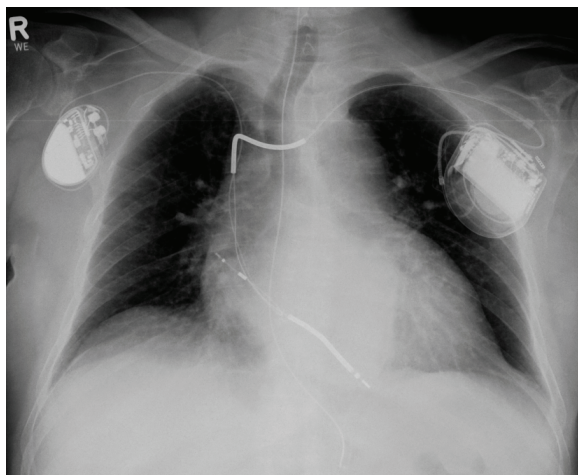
Chest x-ray PA. Male patient, ICD implantation for secondary prevention (Marquis VR 7230, Medtronic, lead dual coil true bipolar). Three years later implantation of a bipolar AAI pacemaker (Insignia I Ultra, Boston Scientific) on the right side because of sinus bradycardia with preserved atrioventricular conduction. The left subclavian vein was found to be occluded.
